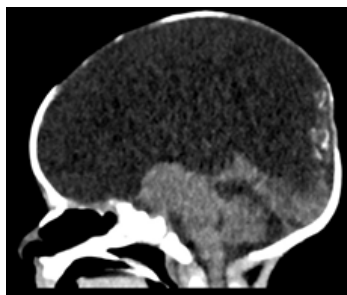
Plain CT Brain Mid-Sagittal section (Brain window) – CSF density near completely replacing the cerebral cortex with remnant cerebral cortex and posterior falx hyperdensities.
